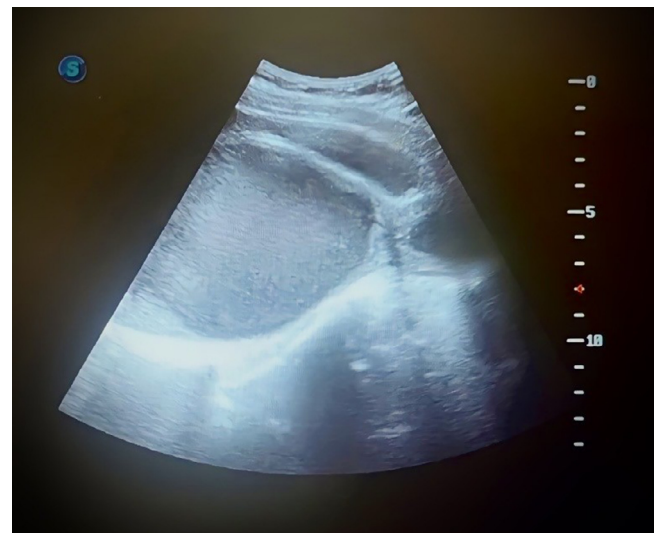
Ultrasound imaging of hematocolpometra. The figure depicts that the vagina and uterus are filled with fluid, suggesting a diagnosis of hematocolpometra.
